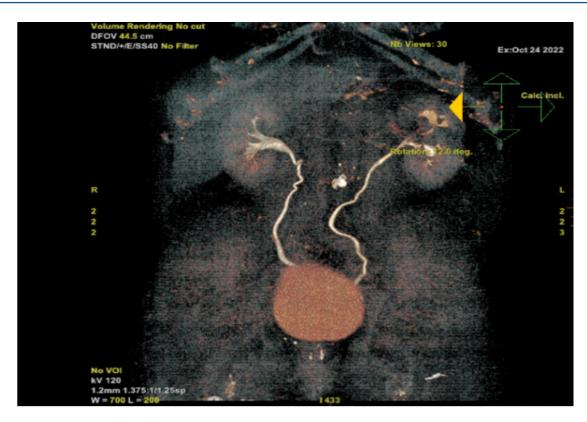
CT Urography study indicative of left pyelonephritis.
